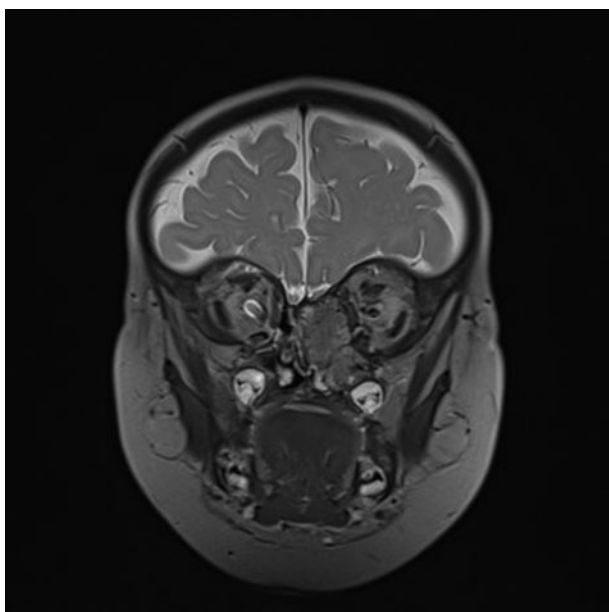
Pre-operative coronal plane magnetic resonance image for patient 2.
